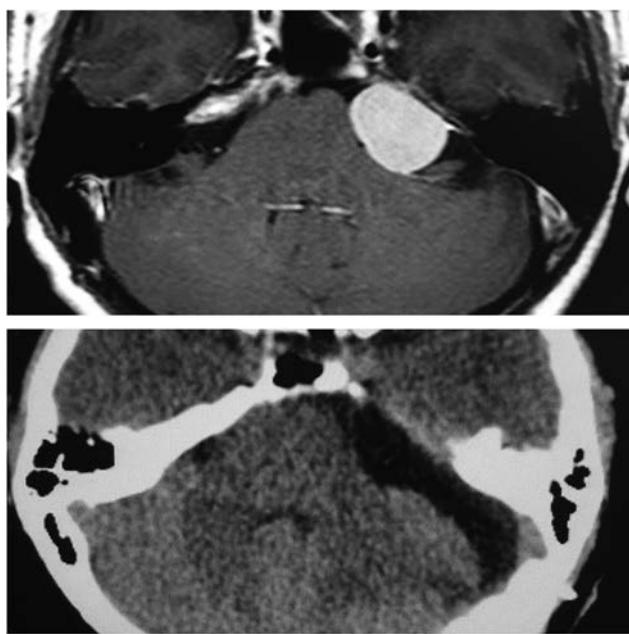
Cerebellopontine angle tumor meningioma compressing the trigeminal nerve. Postoperative computed tomography.
